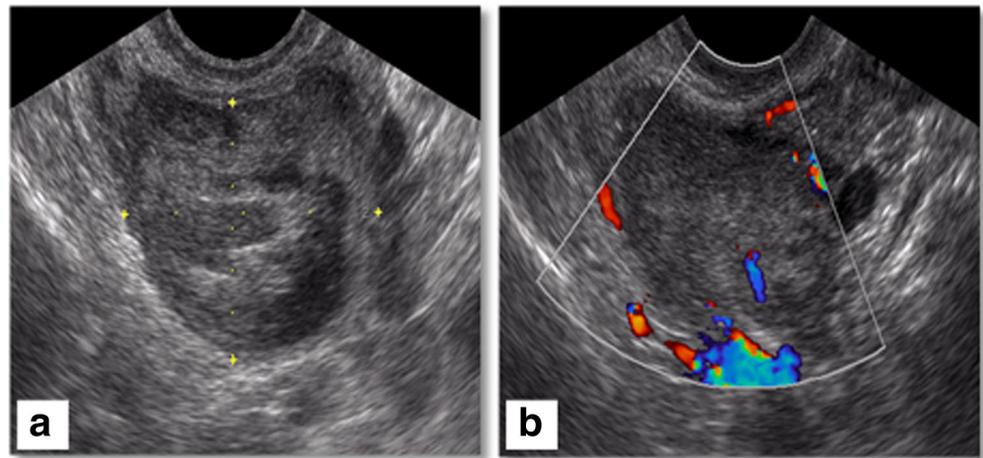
a Transvaginal ultrasound reveals a left adnexal complex cystic lesion with fine internal reticulation (web-like appearance) and scattered echos within the fluid. b Color Doppler examination reveals no internal
